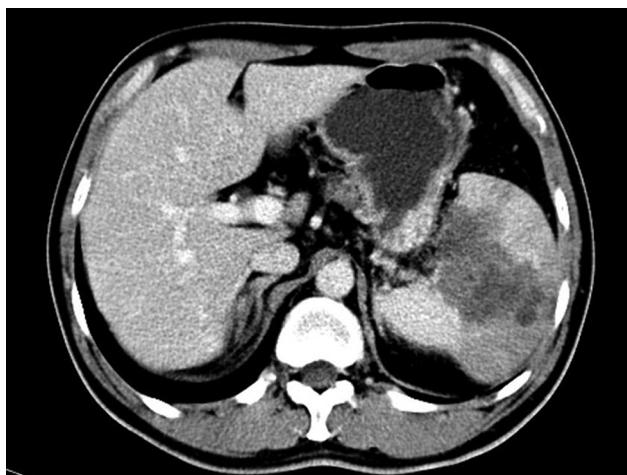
A contrast-enhanced CT scan of the abdomen showing a large heterogeneous mass within the enlarged spleen.
